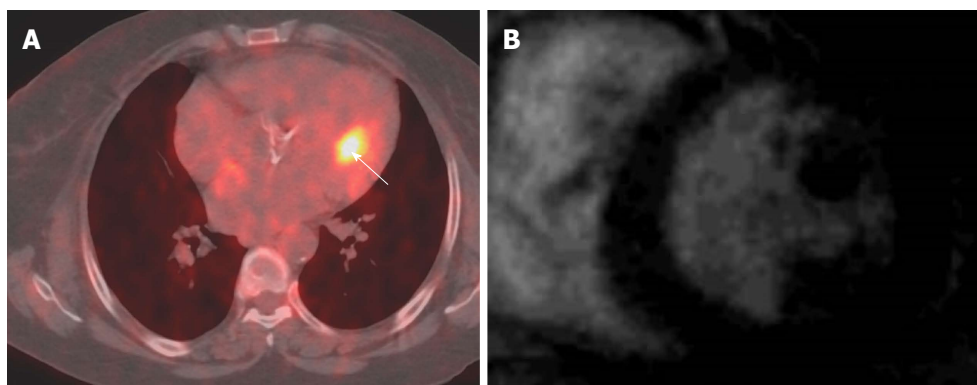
Localization of abnormal fluorodeoxyglucose activity in the heart. A: Axial fused PET-CT image shows focal intense FDG uptake in the heart (arrow) in patient with melanoma that thought represents cardiac metastases; B: Selected delayed enhancement short axis image of the same patient with other images (not shown) shows no abnormal enhancement or tissue infiltration, the FDG uptake was corresponding to hypertrophic papillary muscle, follow PET-CT was normal. PET: Positron emission tomography; CT: Computed tomography; FDG: Fluorodeoxyglucose.
